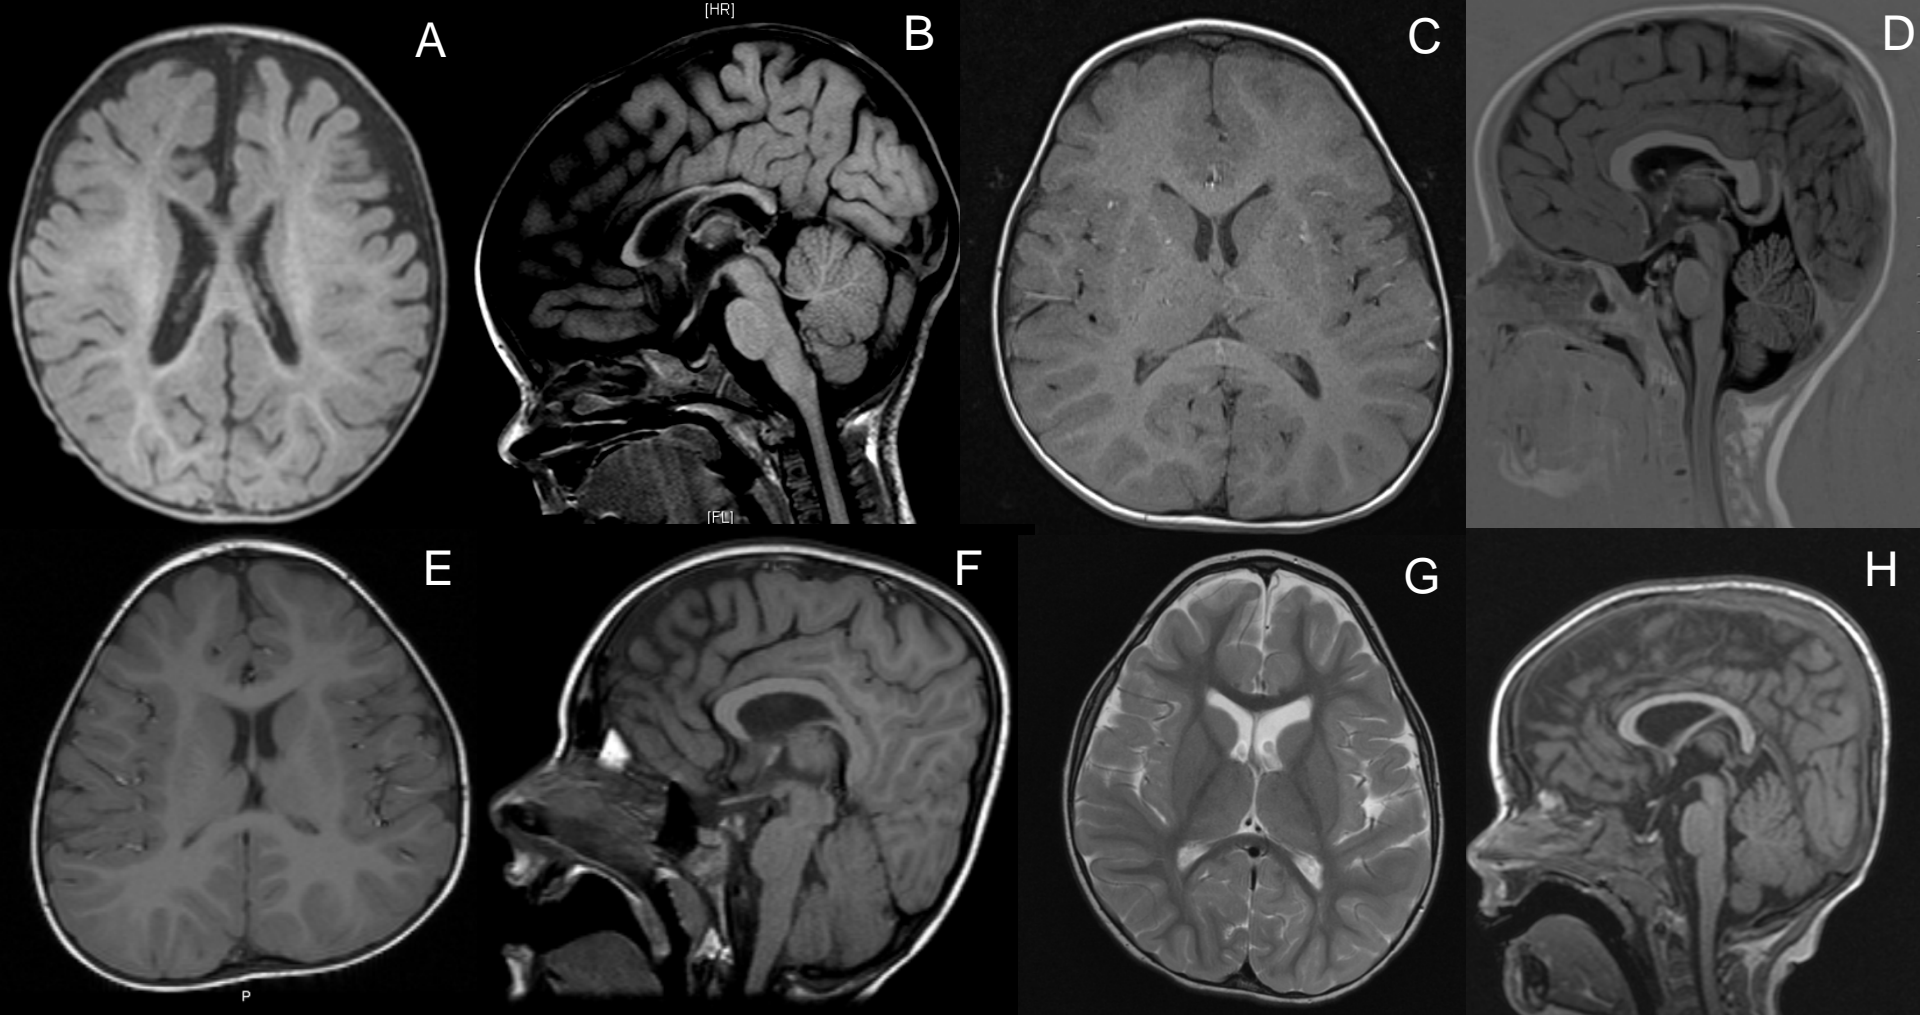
Neuroimaging results. (A) Axial T1-weighted image and (B) sagittal T1-weighted image of Subject F1-IV.1 at 10 months. There is global reduction of cerebral volume and thinning of the corpus callosum. (C) Axial T1-weighted image and (D) sagittal T1-weighted image of F2-V.5 at 2 years, (E) Axial T1-weighted image and (F) sagittal T1-weighted image of F3-II.1 at 6 years, (G) Axial T1-weighted image and (H) sagittal T1-weighted image of F3-II.2 at 2.5 years, demonstrating normal results.
